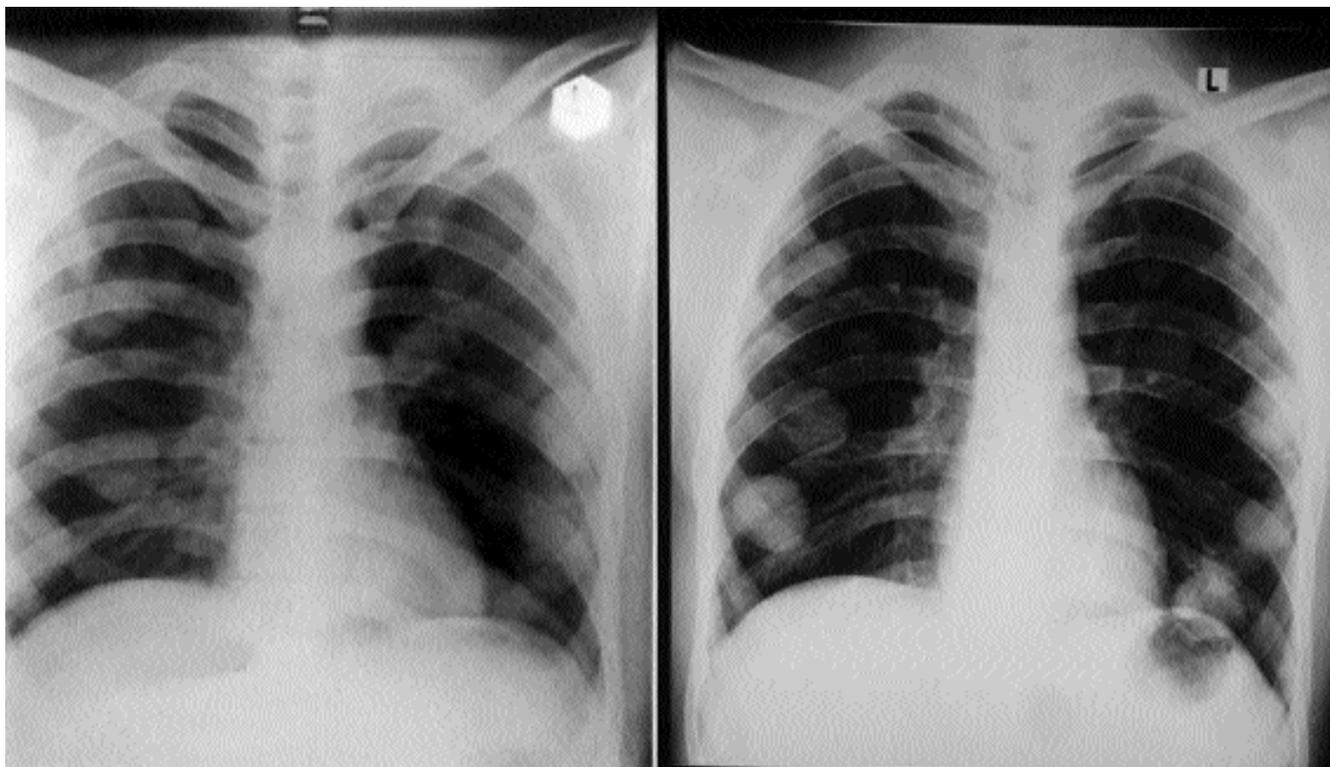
Pre & post chemotherapy X-ray chest showing progressive bilateral coin shaped metastasis.
